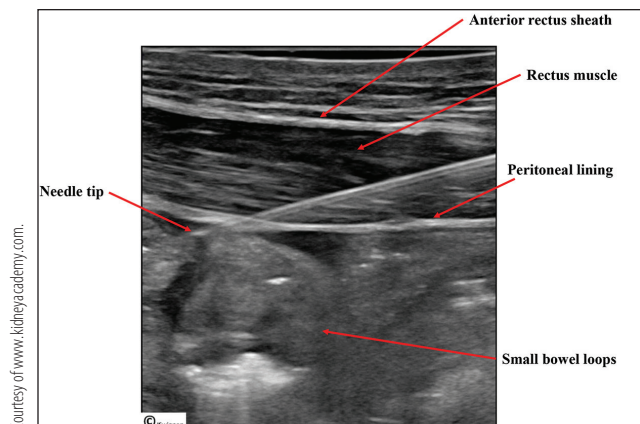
The pertinent abdominal wall structures by ultrasound appearance are marked. The bright (parietal) peritoneal lining is the key layer.
